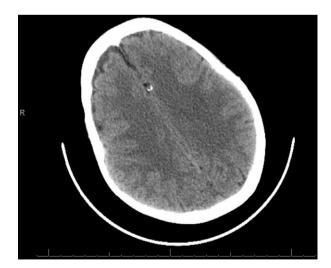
Cranial CT showing bilateral frontal chronic collections, with no apparent parenchymal findings.
